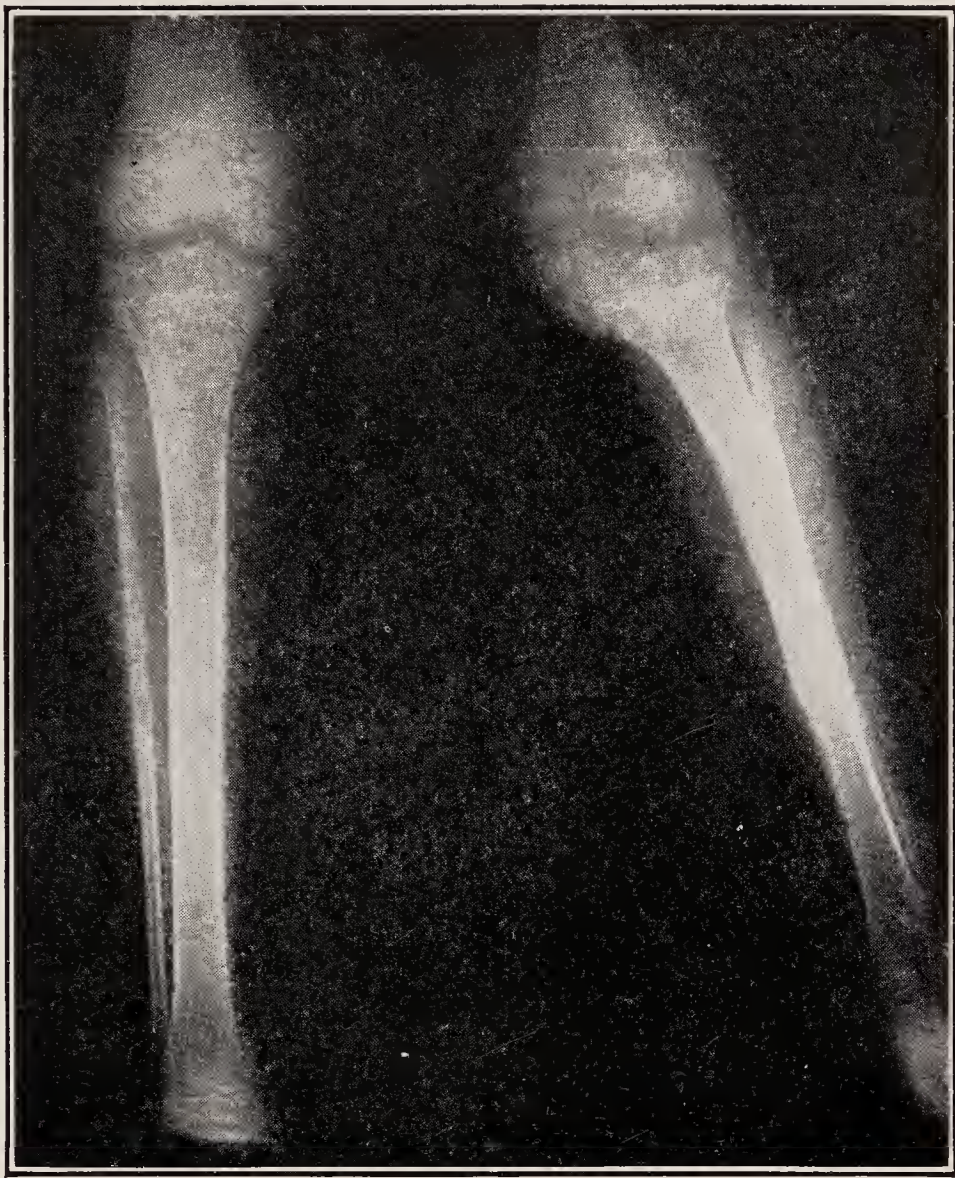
X-ray of dislocation of the lateral condyle of the femur on right of picture, causing knock-knee.
